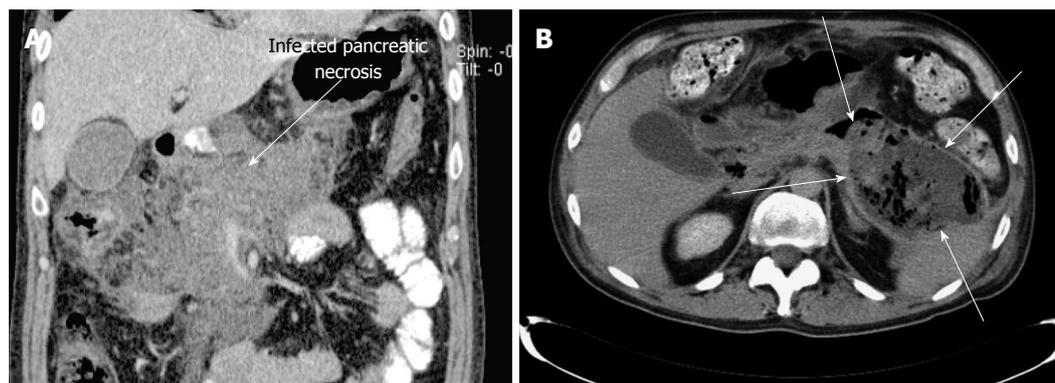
Computed tomography. A: Computed tomography (CT) appearance of the infected pancreatic necrosis, which involves the entire pancreas (marked by an arrow); B: CT appearance of a large pancreatic walled-off necrosis in the tail of the pancreas (marked by arrows).
